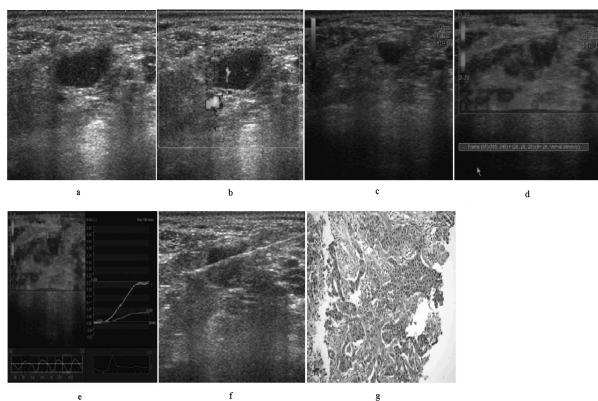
A 61-year-old Woman with Enlarged Cervical LN of Right Neck. (a) the short-axis diameter of this LN was 6.5 mm, less than 8mm. (b) the PDI was typed II; (c, d, e) after compression, the elastogram was obtain. It was scored as 4 point and the SR was 4.22; (f, g) the LN was undergone a biopsy with ultrasound-guided, and the pathology of this LN was adenocarcinoma. Short-axis diameter was misdiagnosis, but UE was correct diagnosis
